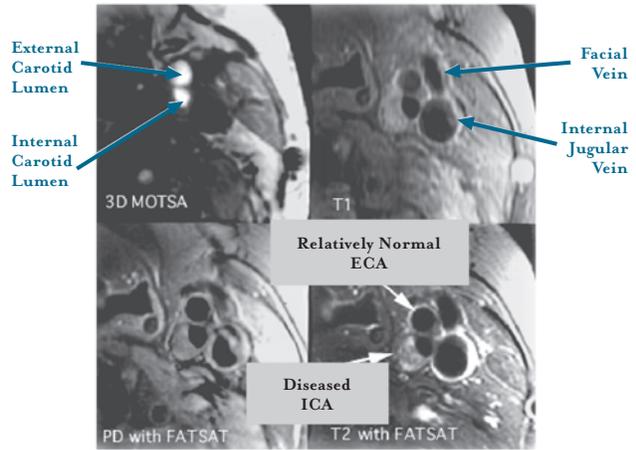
appearance of eccentric plaque in the internal carotid artery on time-of-flight MRA (3D MOTSA), T1-, proton density (PD-), and T2- weighted MRI. The four cross-sectional views are taken at the same level of the carotid artery. MOTSA is an ME angio technique where the lumen is bright. T1, PD and T2 weighted images highlight the plaque features. ICA = internal carotid artery, ECA = external carotid artery.
